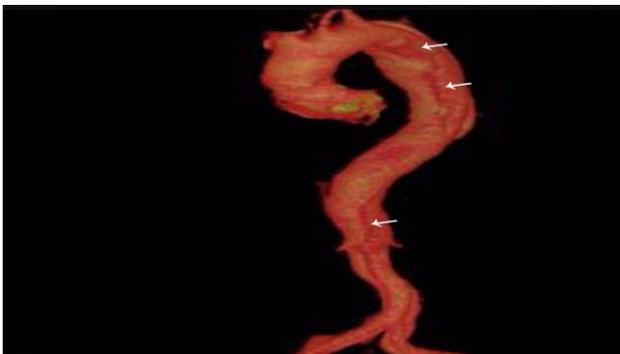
CT angiogram depicting aortic dissection from arch to descending aorta
